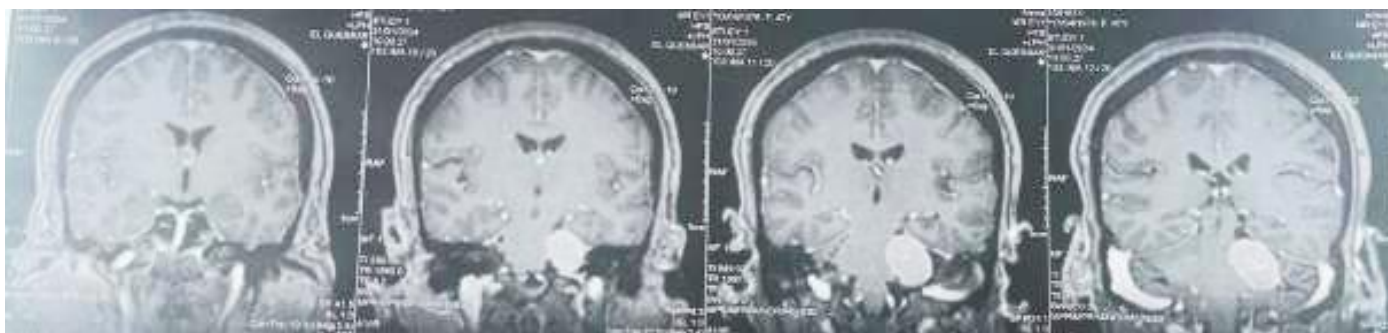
Contrast-enhanced T1-weighted MRI showing a left cerebellopontine angle mass with homogeneous enhancement, slightly extending toward the internal auditory canal without significant enlargement
